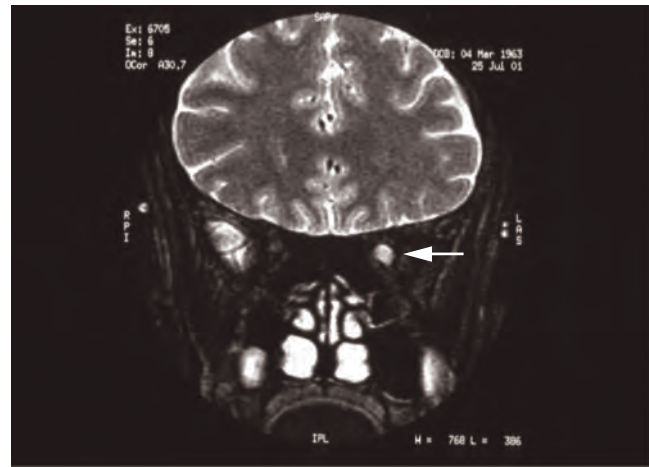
Acute optic neuritis. High signal from a swollen left optic nerve (MRI T2W fat suppression).
